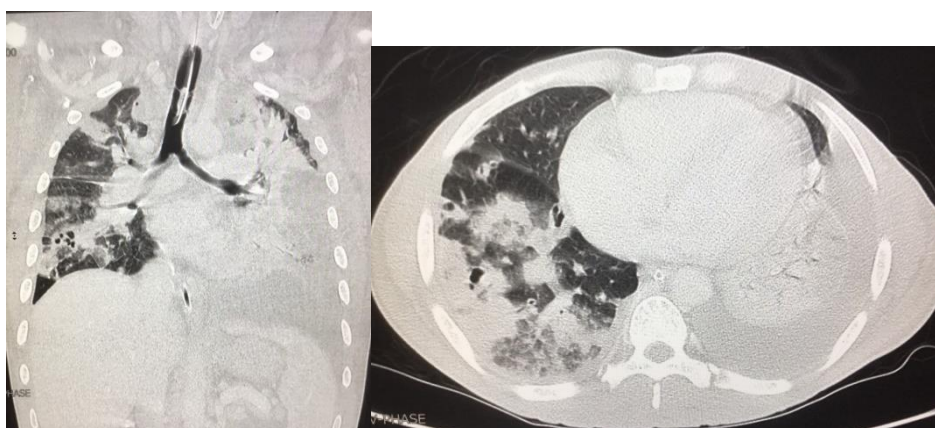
Computed tomography scan of the chest showing multifocal subpleural wedge-shaped consolidation and ground-glass infiltration at right lung, some of them have central cavities. Left pleural effusion causes passive left lung atelectasis.
